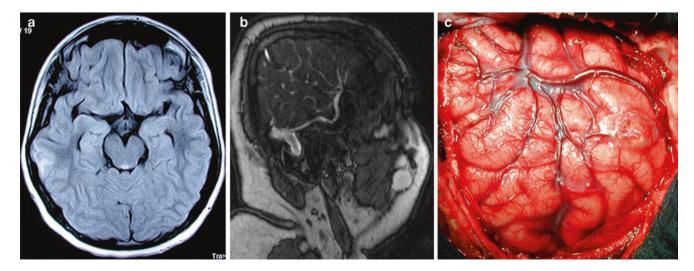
In a 22-year-old man with a long history of stress-induced complex partial seizures, preoperative magnetic resonance imaging demonstrated a well-defined neocortical lesion in the right posterior temporal
